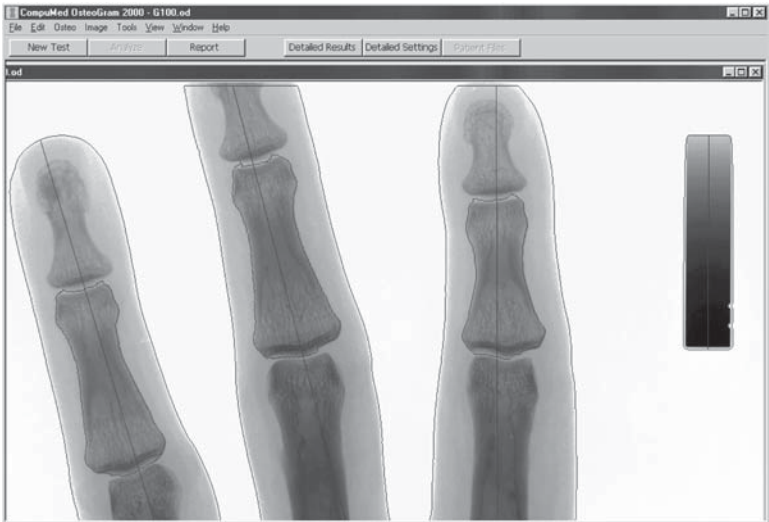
A radiographic absorptiometry analysis of the mid-phalanges of the index, long, and ring fingers. Case provided courtesy of CompuMed Inc., Los Angeles, CA.
